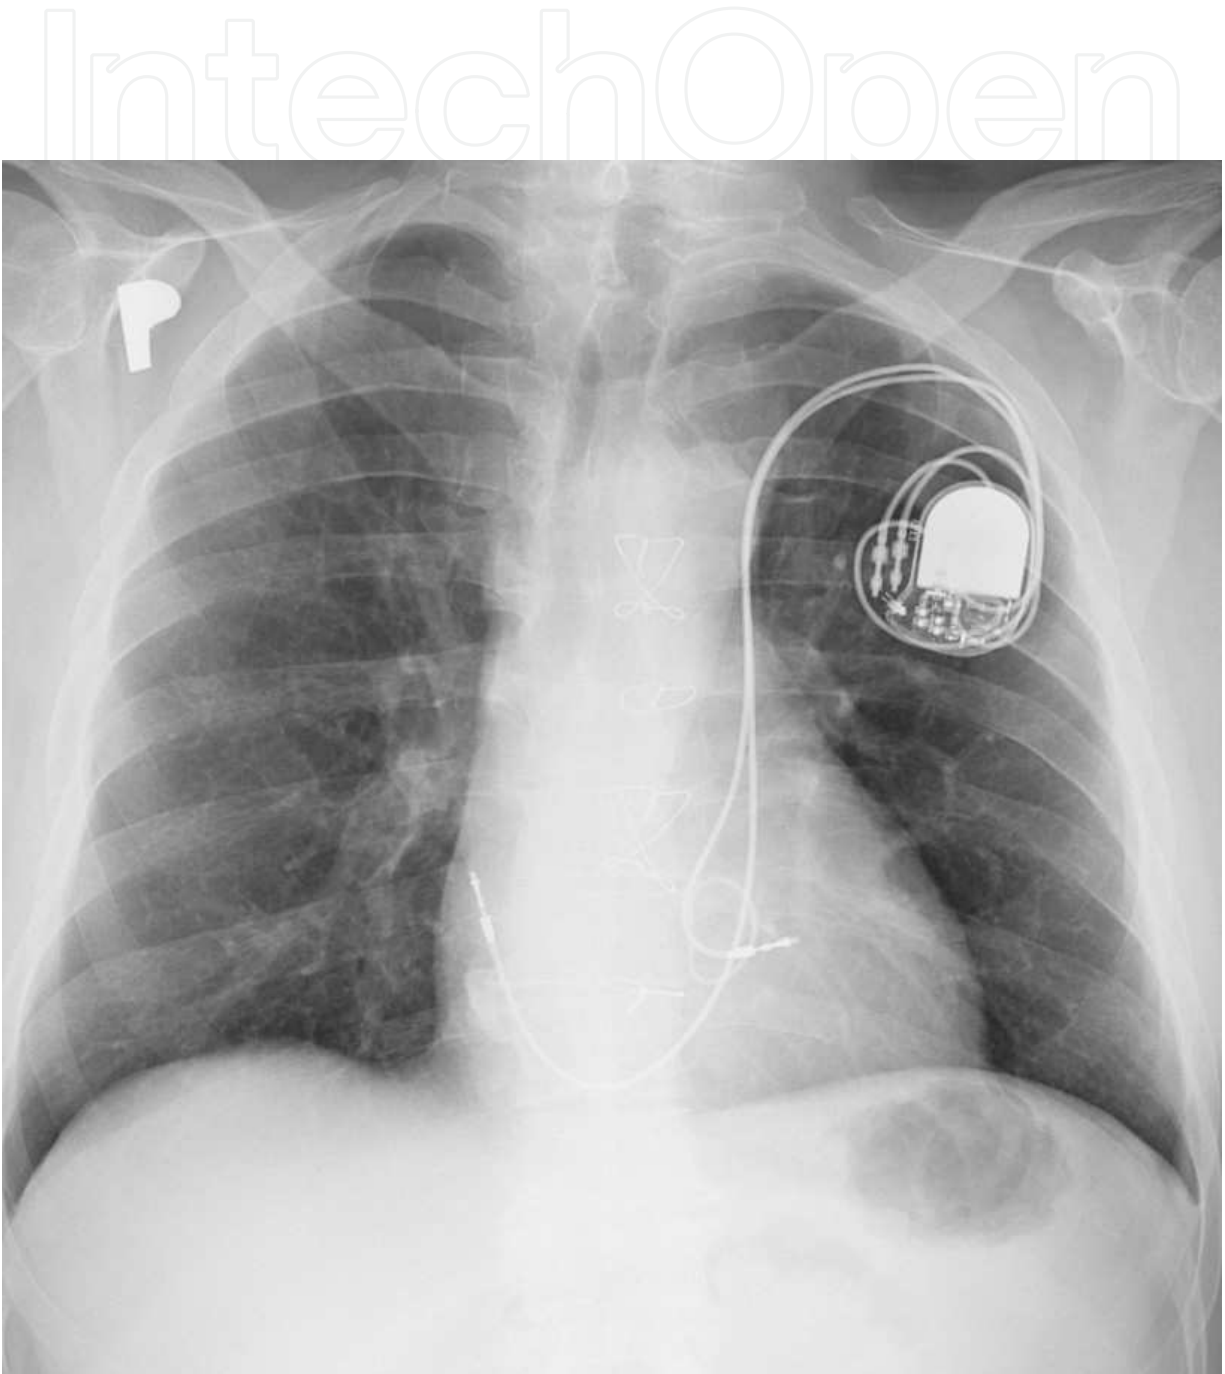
Anteroposterior chest radiograph. Pacemaker electrodes passing through left-sided SVC, entering distal coronary sinus.
